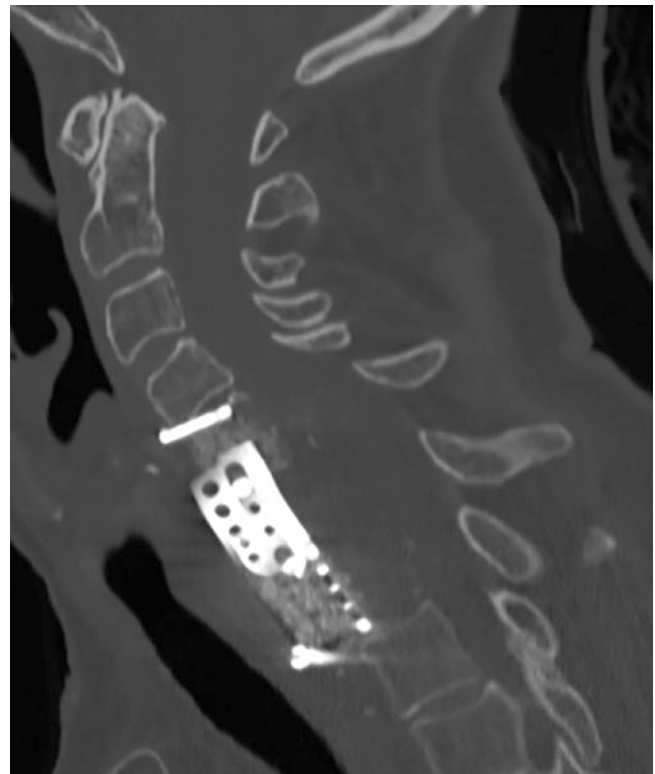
Sagittal cervical CT scan documenting further expandable cage (without anterior plating) displacement
